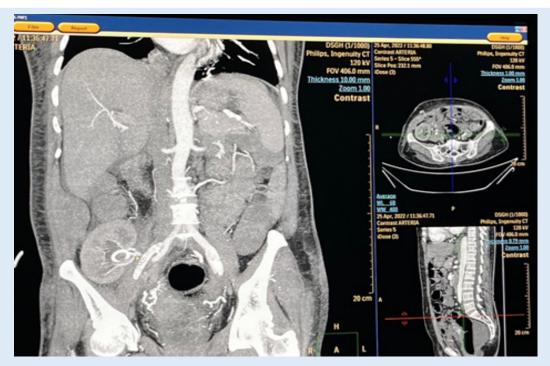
CT renal angiogram showing normal renal artery and vein.
